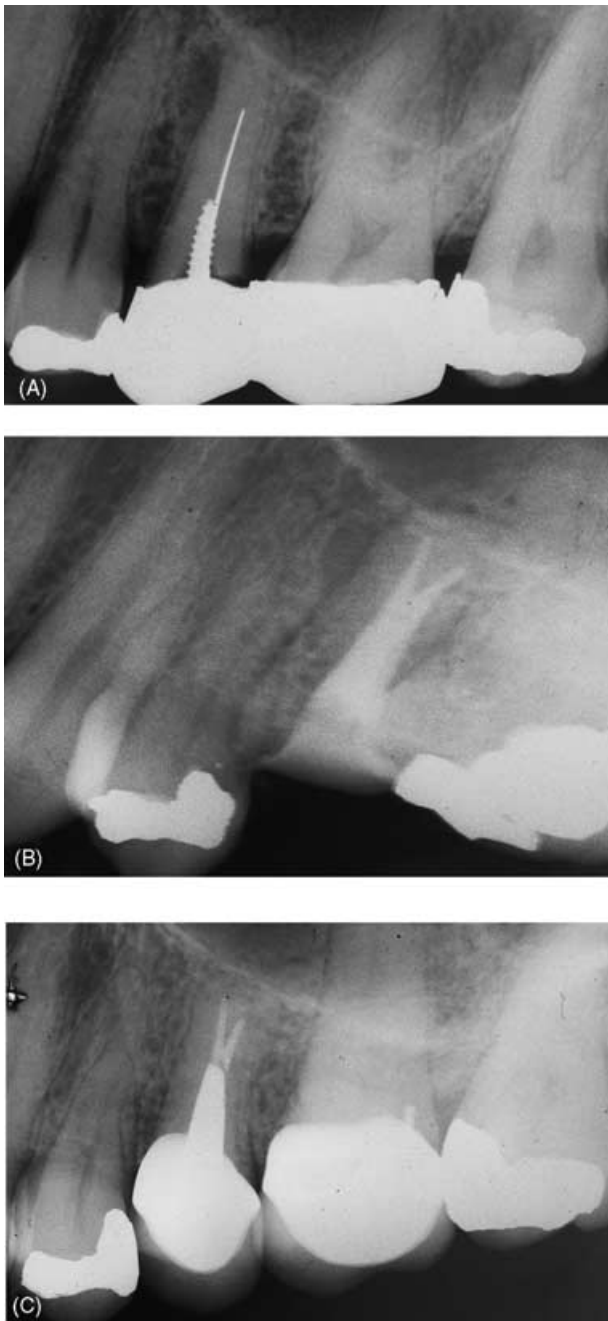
Poor coronal seal in a maxillary second premolar. (A) Radiograph showing inadequate coronal restoration and root canal treatment. Note the lateral apical lesion associated with the tooth. (B) Radiograph taken upon completion of endodontic retreatment. The old restoration was removed and the canal system properly prepared and obturated. (C) Five-year follow-up radiograph showing bony repair. The tooth was adequately restored with post and crown.
